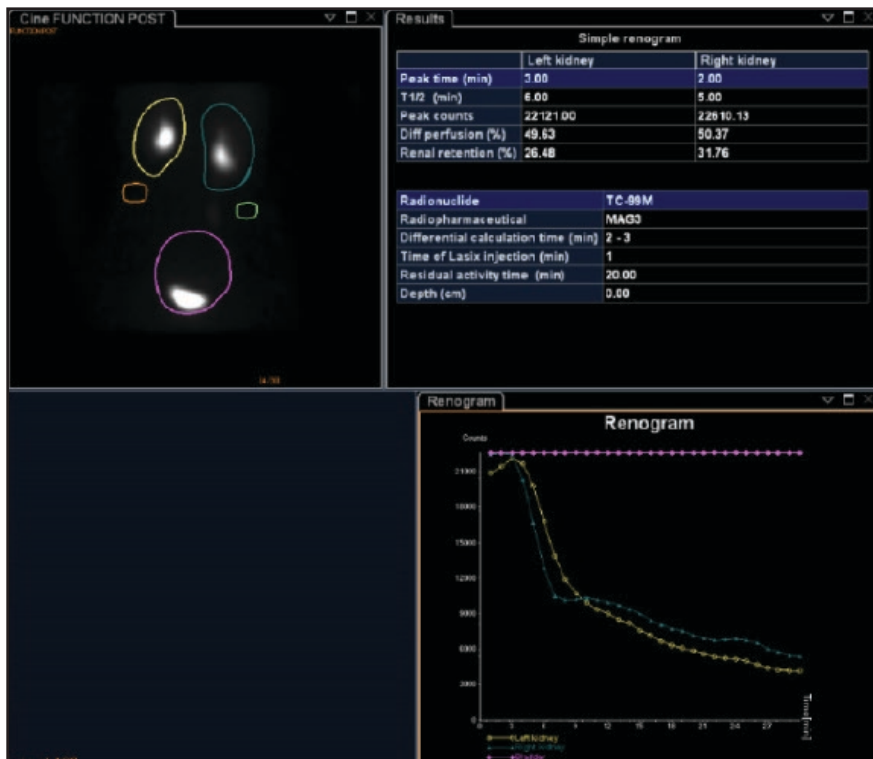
Diuretic renography with furosemide and Tc-99m MAG3 administered at the same time (F+0 protocol). Postfurosemide renogram in a patient with right-sided hydronephrosis noted on renal ultrasound demonstrating normal washout of radiotracer with a T1/2 of 5 minutes on the right, excluding mechanical obstruction.
